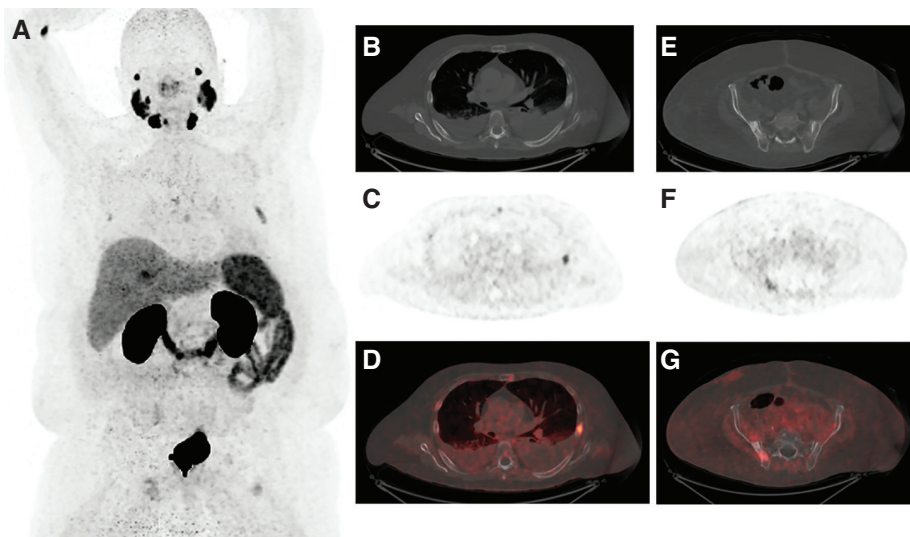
An 82-year-old man with metastatic prostate cancer, but with limited PSMA expression of disease, ineligible for ^{177}Lu -PSMA-617 RLT. A. Maximum intensity projection image of the chest demonstrating one osteoblastic rib lesion and mild uptake in the sternal body and a right-sided rib; C. axial PSMA PET image demonstrating uptake related to the osteoblastic rib lesion and mild uptake in the sternal body and a right-sided rib; D. fused PET/CT images of B and C; E. axial CT image demonstrating an osteoblastic right iliac bone lesion; F. PSMA PET image demonstrating limited uptake associated with the osteoblastic lesion; G. fused images of E and F.
